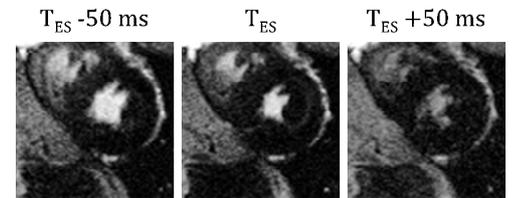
T1-weighted images obtained using three trigger times in a real-time feedback experiment. The LV blood pool region in the image obtained using T_{ES} is the smallest.
